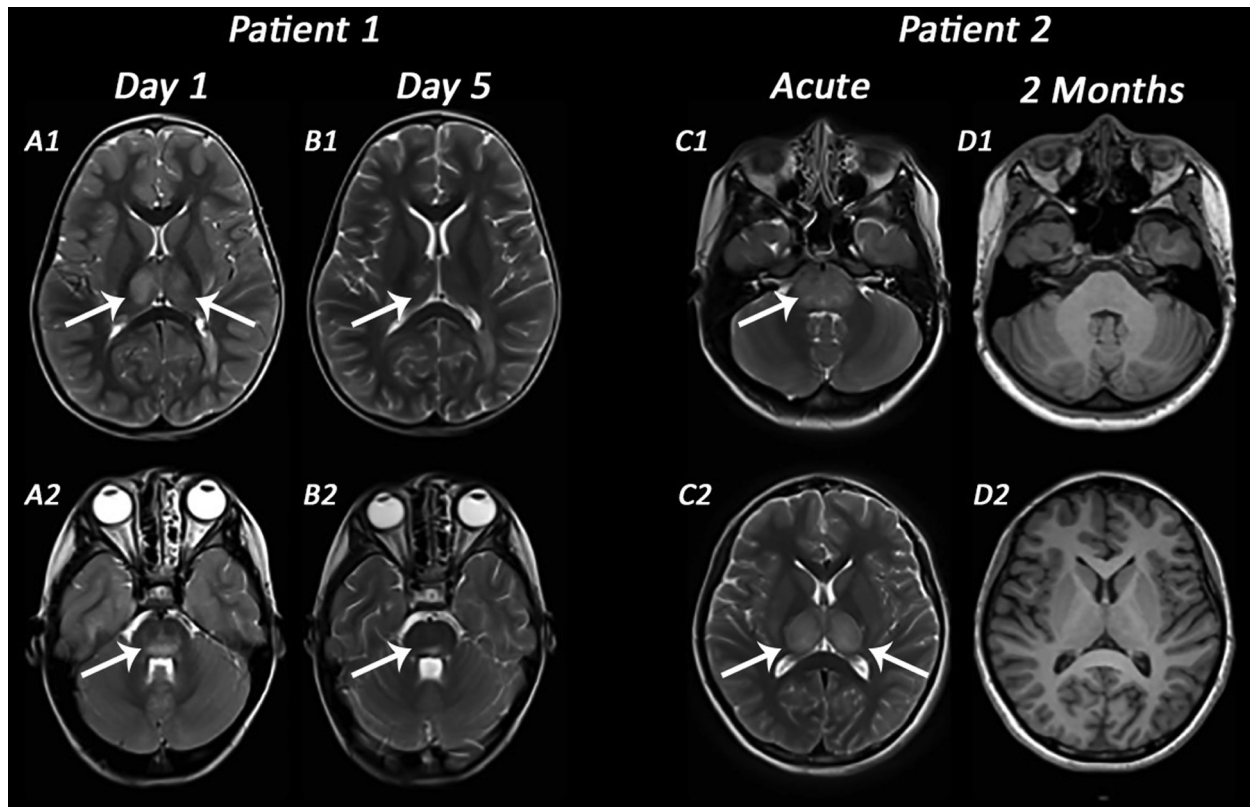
Magnetic resonance brain imaging for two patients with good clinical and radiological outcome. Patient 1: A and B, axial T2-weighted images. Hyperintense lesions in the pontine tegmentum and bilateral thalami (A1, A2, white arrows) on day one (16 hours of encephalopathy) with significant improvement in lesions on day five (B1, B2, white arrows). Patient 2: C, axial T2-weighted images and D, axial T1-weighted images. Hyperintense expansile lesions in the pons and bilateral thalami (C1, C2, white arrows) in the acute phase are completely resolved on the follow-up scan at two months after illness (D1, D2).
